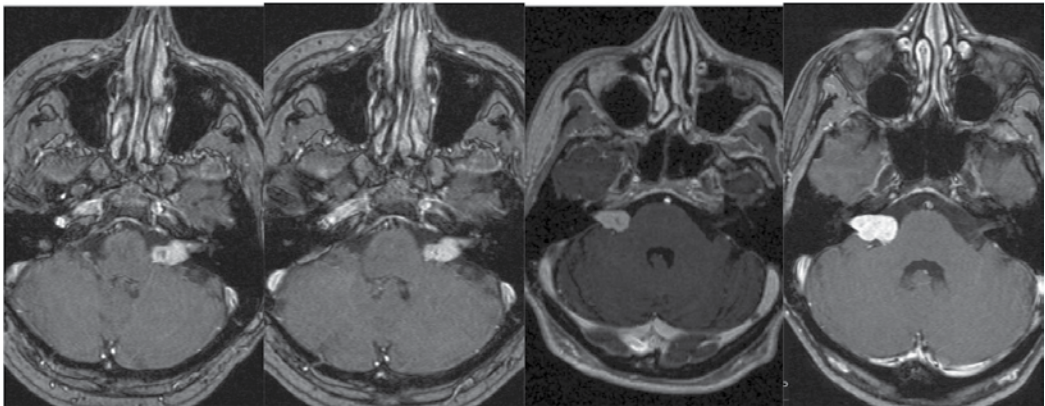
Axial MRI (T1-with contrast) of two cases of VS treated with Gamma Knife radiosurgery (13 Gy marginal dose) with follow-up MRI showed good tumor control after 15 months (case on the left side) and after 29 months (case on the right side).
